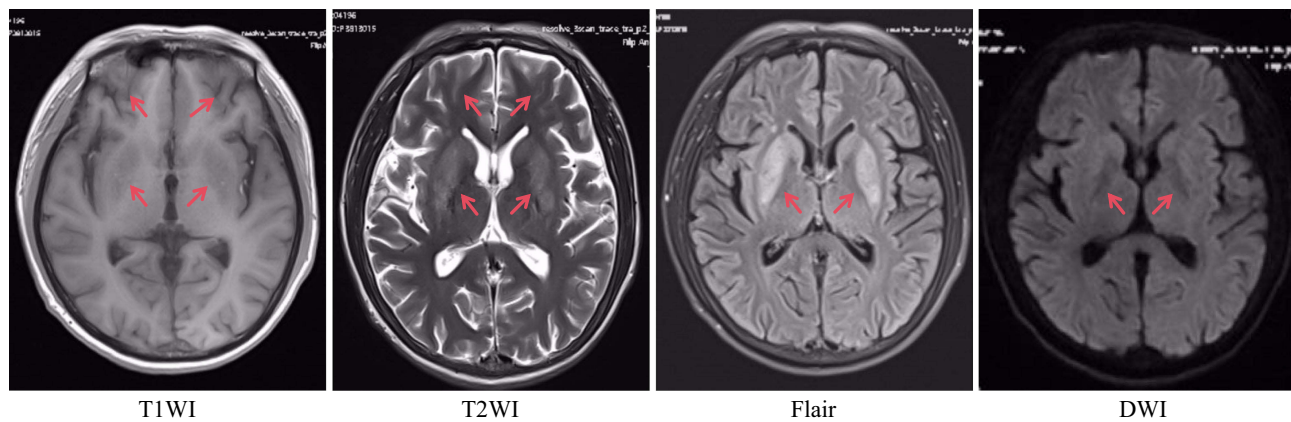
Case 2. Speckled abnormal signal shadows in the bilateral frontal subcortex and adjacent to the ventricles bilaterally, as well as symmetric abnormal signal shadows in the bilateral basal ganglia. The red arrows point to the lesions. These areas exhibited iso-low signals in T1-weighted images (T1WI) and diffusion-weighted imaging (DWI), iso-high signals in T2-weighted images (T2WI), and high signals in flair sequences.
